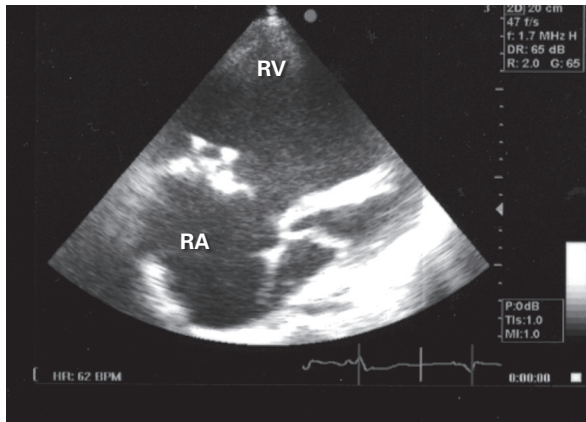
Transthoracic echocardiogram in 4-chamber view shows the severely enlarged right ventricle and dehiscence of the bioprosthetic tricuspid valve.
